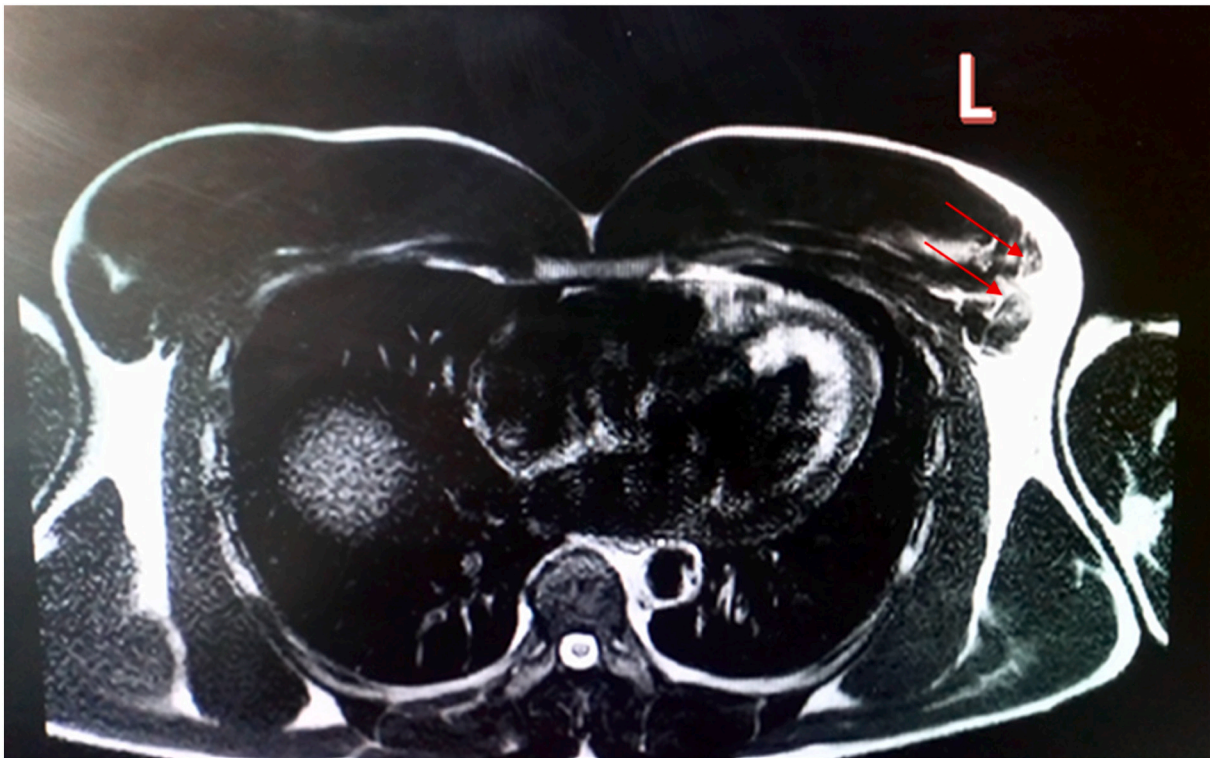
Transversal MRI T2 shows the clear tear in the musculotendinous junction of the left Pectoralis Major muscle in comparison to the right one (see the rounded ruptured ends with the red arrows). (For interpretation of the references to colour in this figure legend, the reader is referred to the web version of this article.)
